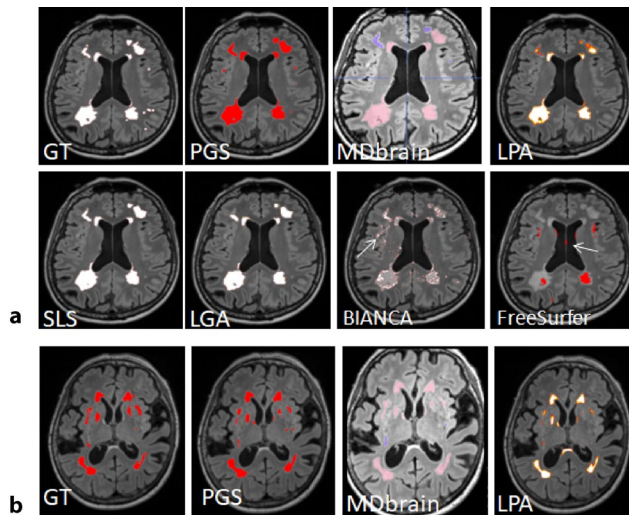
208 (a) Example of the same axial FLAIR slice segmented by hand (GT) and with seven automatecl methods. All tools reach a good performante in detecting large confluent WMH surrounding the ventricular area, but their performante variably drops in detecting subcortical/deep WMH, especially when presenting as nonconfluent multifocal spots. For the latter, PGS and MDbrain are more sensitive compared to other tools. False positives are most commonly detected in the septum pellucidum (white arrow—FreeSurfer), choroidal plexus in the lateral ventricles, or in the sulci of temporal lobe regions (white arrow—BIANCA). (b) „WMH challenges” surrounding basal ganglia (depicted in a white arrow—GT) are more accurately detected by PGS, MDbrain and LPA. Images in both panels belong to two different patients
